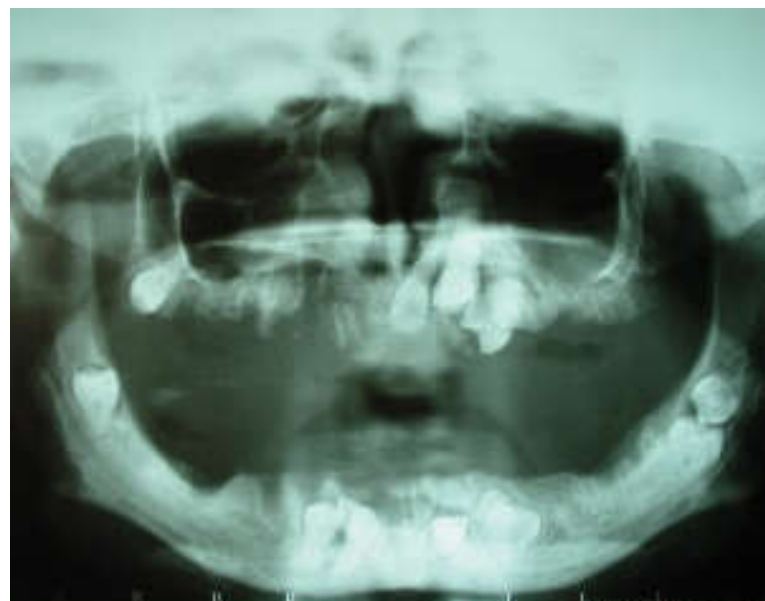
Panoramic X-Ray. Note the supernumerary teeth in the maxilla and mandible
